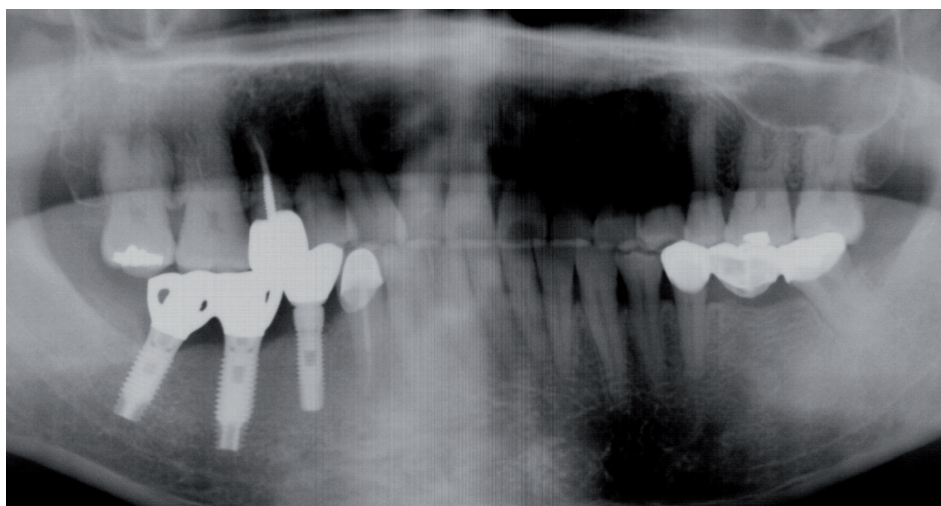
Radiograph taken nine months after treatment. The defect area shows stable results up to the most recent follow-up period.
